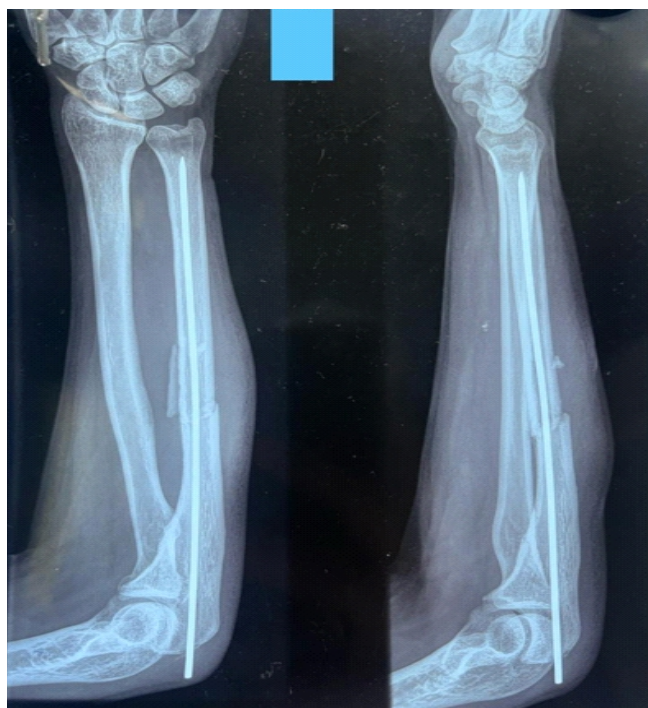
Initial radiograph showing Kirschner wire fixation for midshaft ulna fracture. The fracture is likely to undergo non-union in adult patients, particularly in forearm fractures, where compression and rotational stability at the fracture site are not provided.
